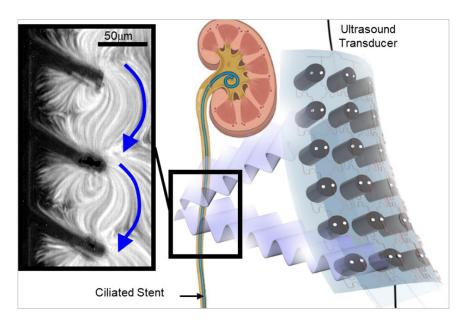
Our envisioned solution for transcutaneous cleaning of urinary stents and catheters using surfaces equipped with ultrasound-activated cilia.
